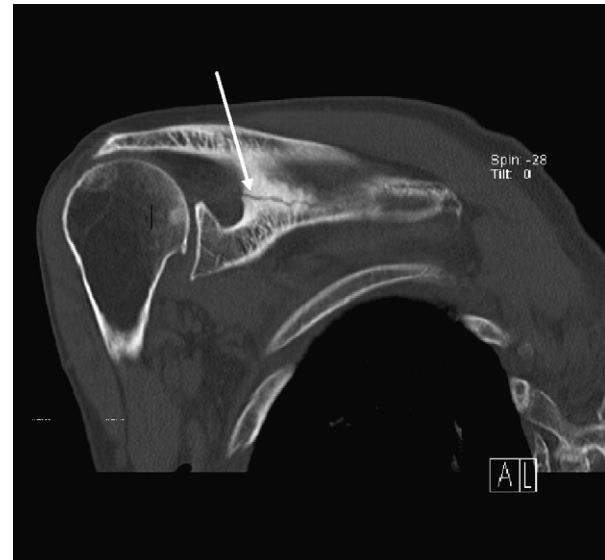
Axial section CT image of the right shoulder showing a fracture through the base of the spine of the scapula.
